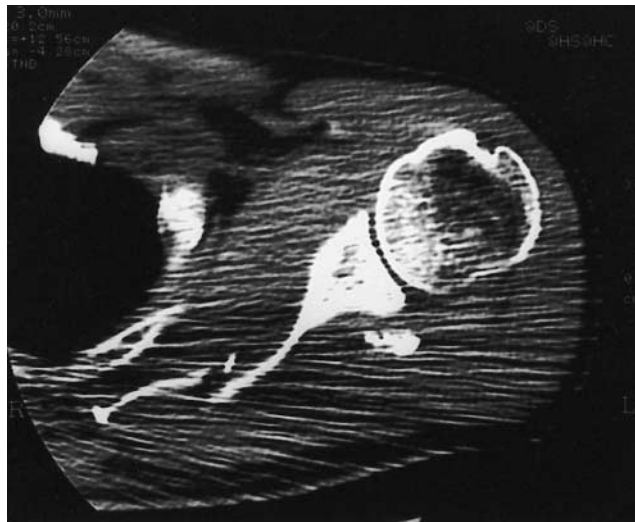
Computed tomographic scan, right shoulder
